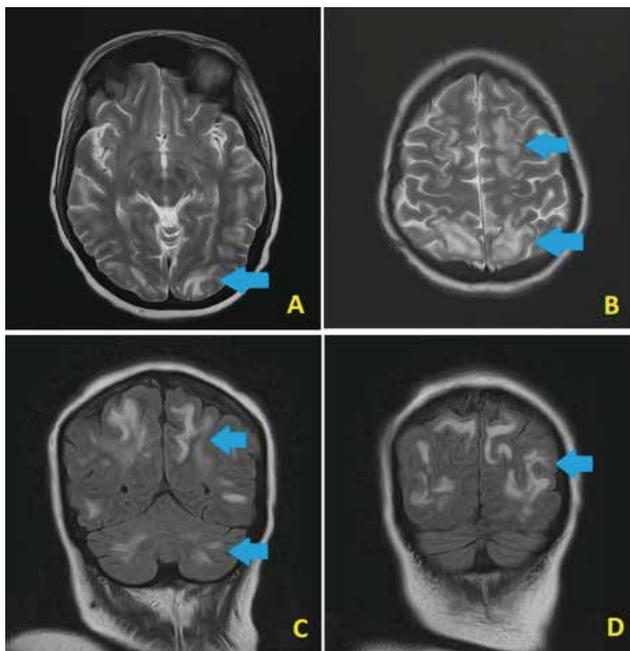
MRI Brain showing diffuse subcortical hyperintense signals in bilateral cerebral hemispheres in T2/FLAIR sequences and T2 hyperintense signals in bilateral cerebellar hemispheres without evidence of diffusion restriction, susceptibility signal or
